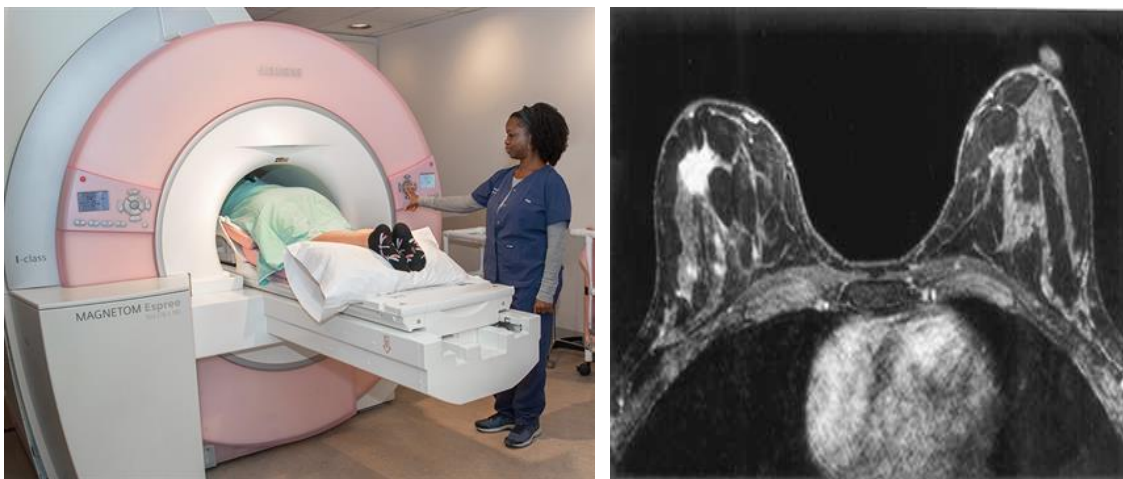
MRI Breast Imaging (left) (Cleveland Clinic, 2019) with Output Image (right) (Robert J Miller, 2020a). The patient must remain perfectly still during the MRI scan, and may be given a sedative to help with this. The scan produces 2D slices of the breast, and other tissues, that are sequenced to form a 3D image for estimating size, shape, and location of the lesion. This displays both breasts at once.
